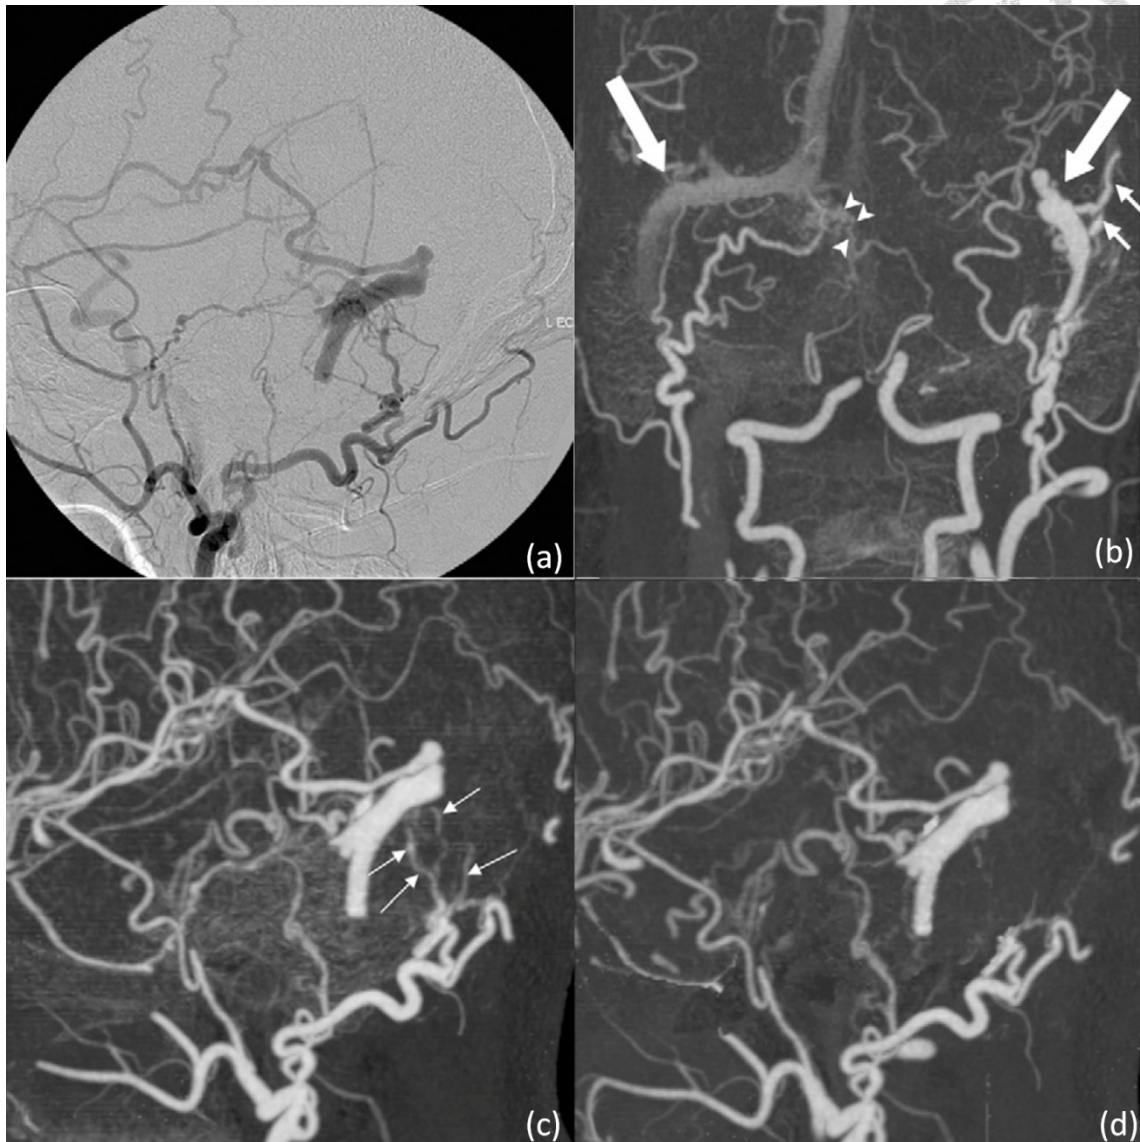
Patient 8. (a) Lateral DSA image after left external carotid injection shows isolated left transverse sigmoid sinus dural AVF. (b) Coronal hybrid CT angiogram shows asymmetric sinus enhancement (large arrows), engorged cortical veins (small arrows), and incidental small right proximal transverse sinus dural AVF (arrowheads). Images from (c) hybrid CTA and (d) MMBE CTA show isolated, occluded transverse sinus. Transosseous enhanced vessels (arrows on c) could be demonstrated only on hybrid CT angiogram.
